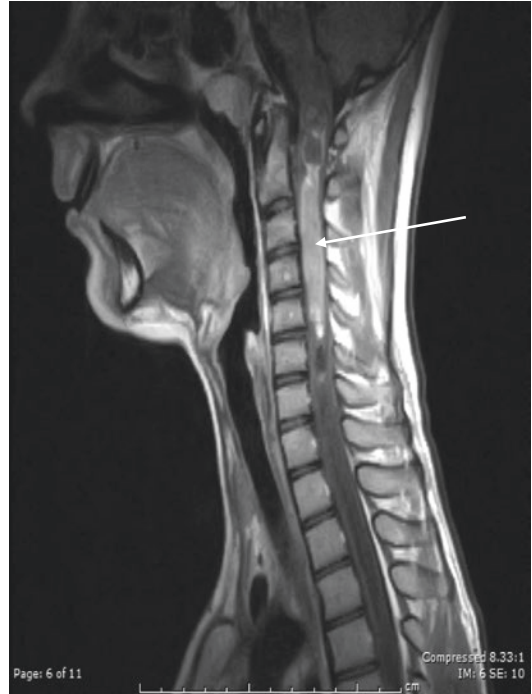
MRI brain showing brain tumor
